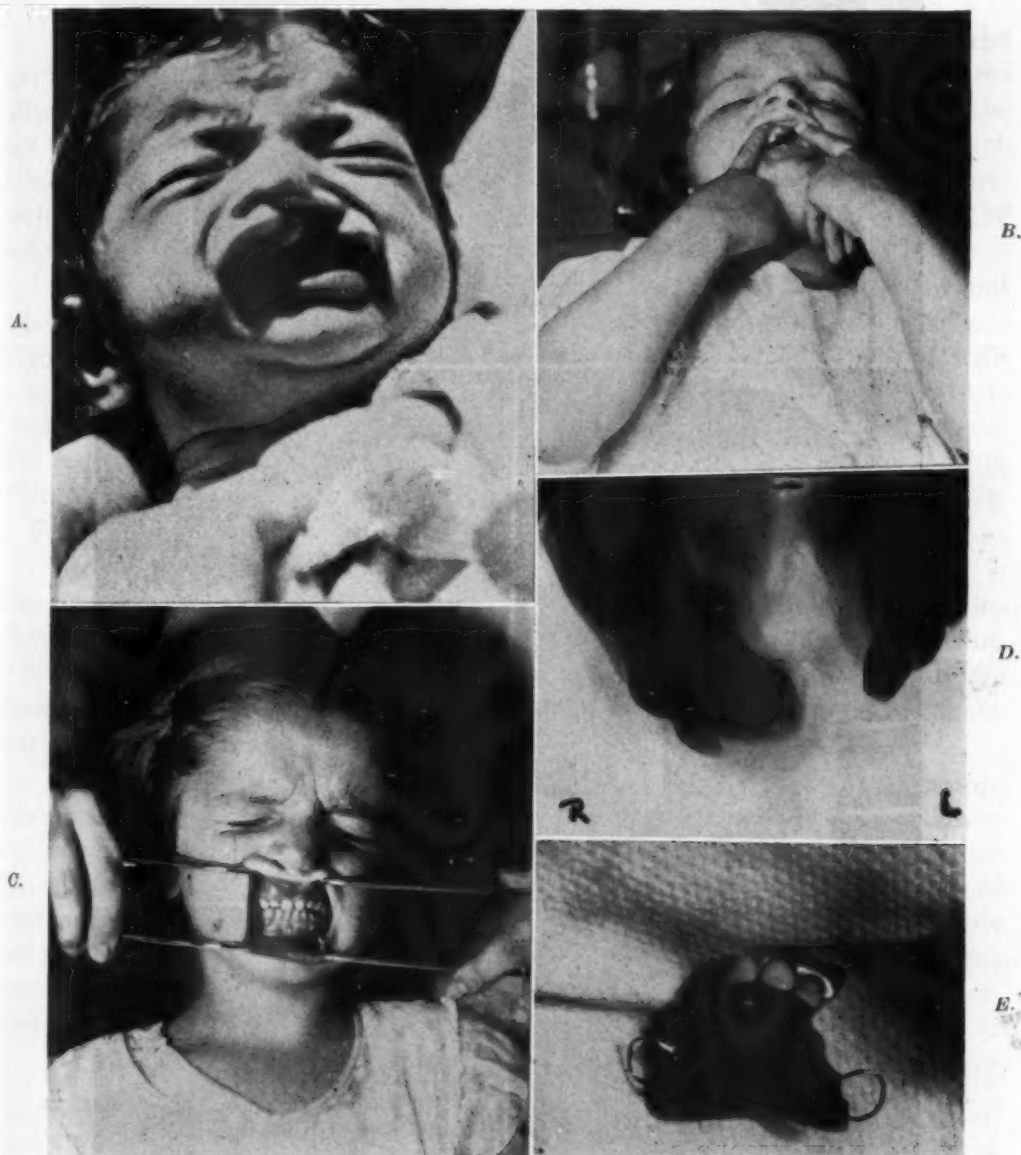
A, Unilateral cleft of lip and complete cleft of hard and soft palates. (Courtesy of the late Carl G. Burdick, M.D.) B, Mouth open showing anterior perforation in hard palate following cleft palate repair, aged 4 years. C, Occlusal view. Obturator containing anterior teeth in position. D, Occlusal roentgenogram showing cleft in hard palate. E, Photograph of obturator with labial flange, spaced anterior teeth (deciduous-shaped), and Jackson crib clasps.
